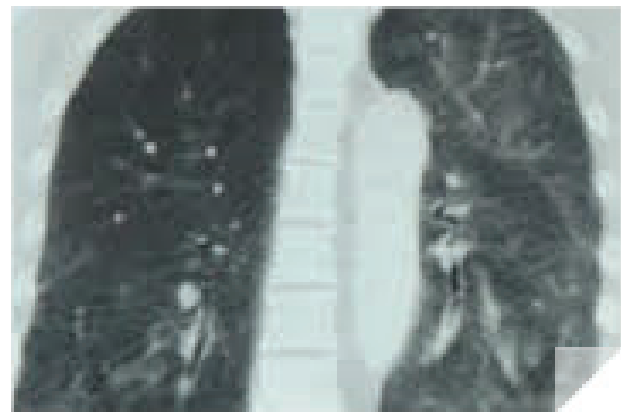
Multislice computed tomography (MSCT) showing an irregularly contoured, 25 × 22 mm and a tape-like, 15 × 8 mm reticular abnormalities of the lungs, in the right middle lobe medial segment, representing pulmonary fibrosis.
